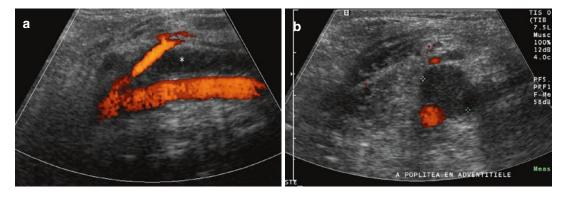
(a, b) Adventitial cystic disease of the popliteal artery. (a) Longitudinal and (b) axial Doppler ultrasound. Note anechoic lesion within the wall of the popliteal artery (asterisks on (a) and calipers on (b)). The lumen of the artery is patent and shows colored Doppler signal. Note also the presence of a small arterial branch
